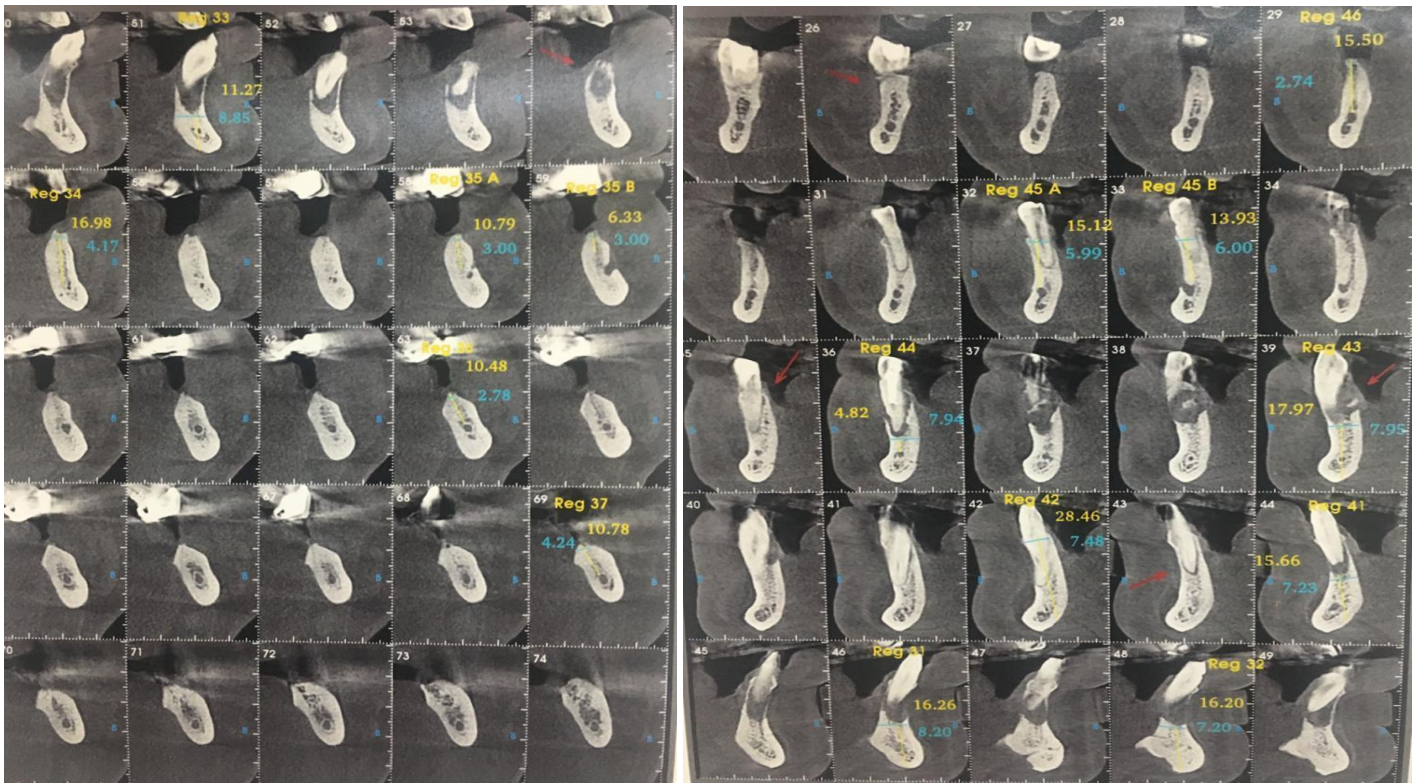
Detail of ICat images from first assessment and periapical lesion in anterior mandibular region.
